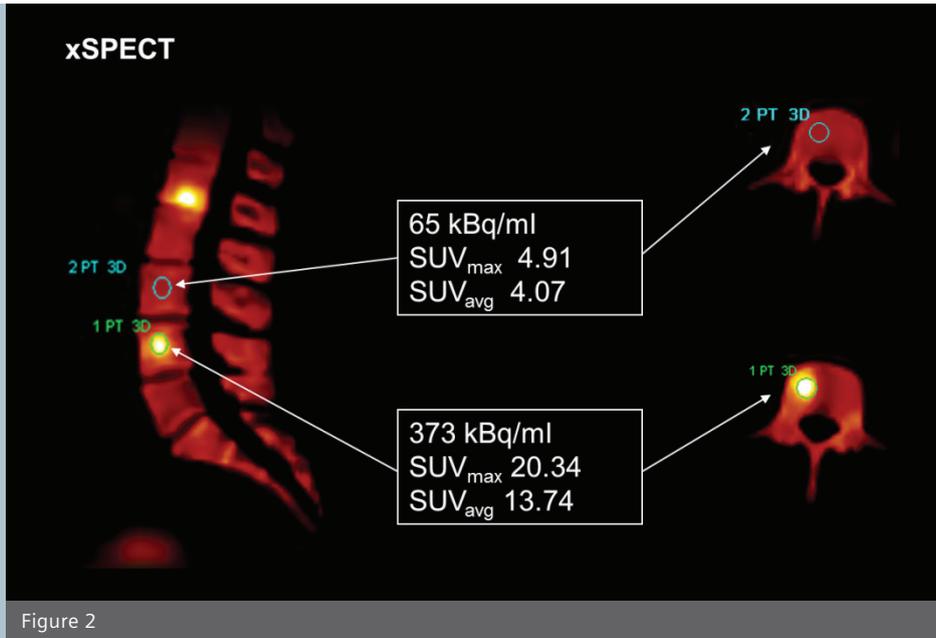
Lumbar vertebral metastases in a patient with lung cancer. xSPECT Quant confirms hot lesions are metastatic with high SUV but also uncovers zones with very low SUV in uninvolved vertebrae, suggesting osteoporosis.
